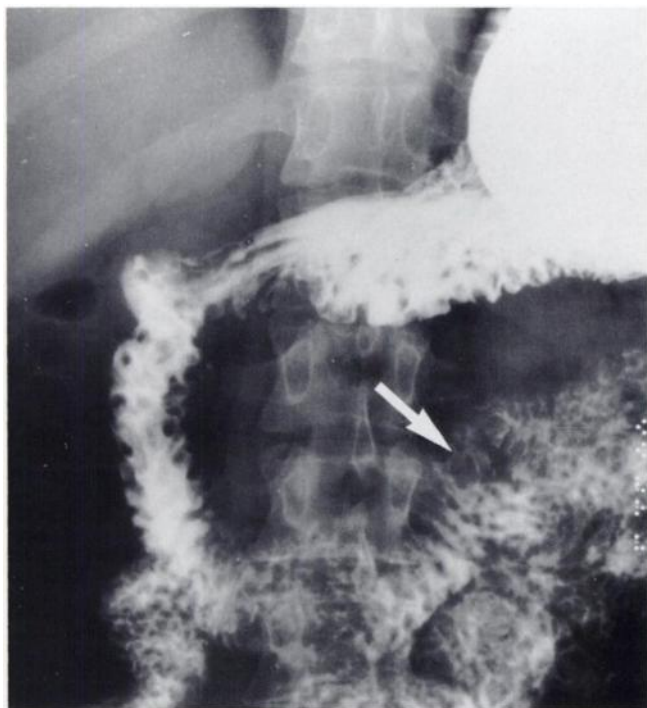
Upper gastrointestinal barium study of the patient whose ^{99m}Tc red blood cell scintigrams are shown in Test Figure 1. There is a filling defect in the barium column in the third portion of the duodenum (arrow). This mass proved to be a rest of ectopic gastric mucosa.
